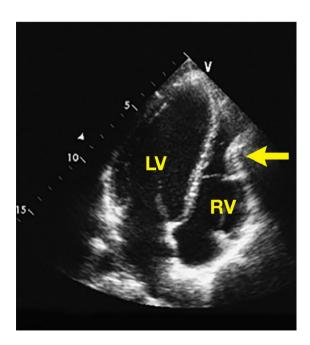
Apical 4-chamber echocardiographic image showing reversed curvature of the free wall of the right ventricle (RV) (arrow). LV = left ventricle (Reproduced with permission from Jaroszewski et al., 10 page 191, Fig. 3)
